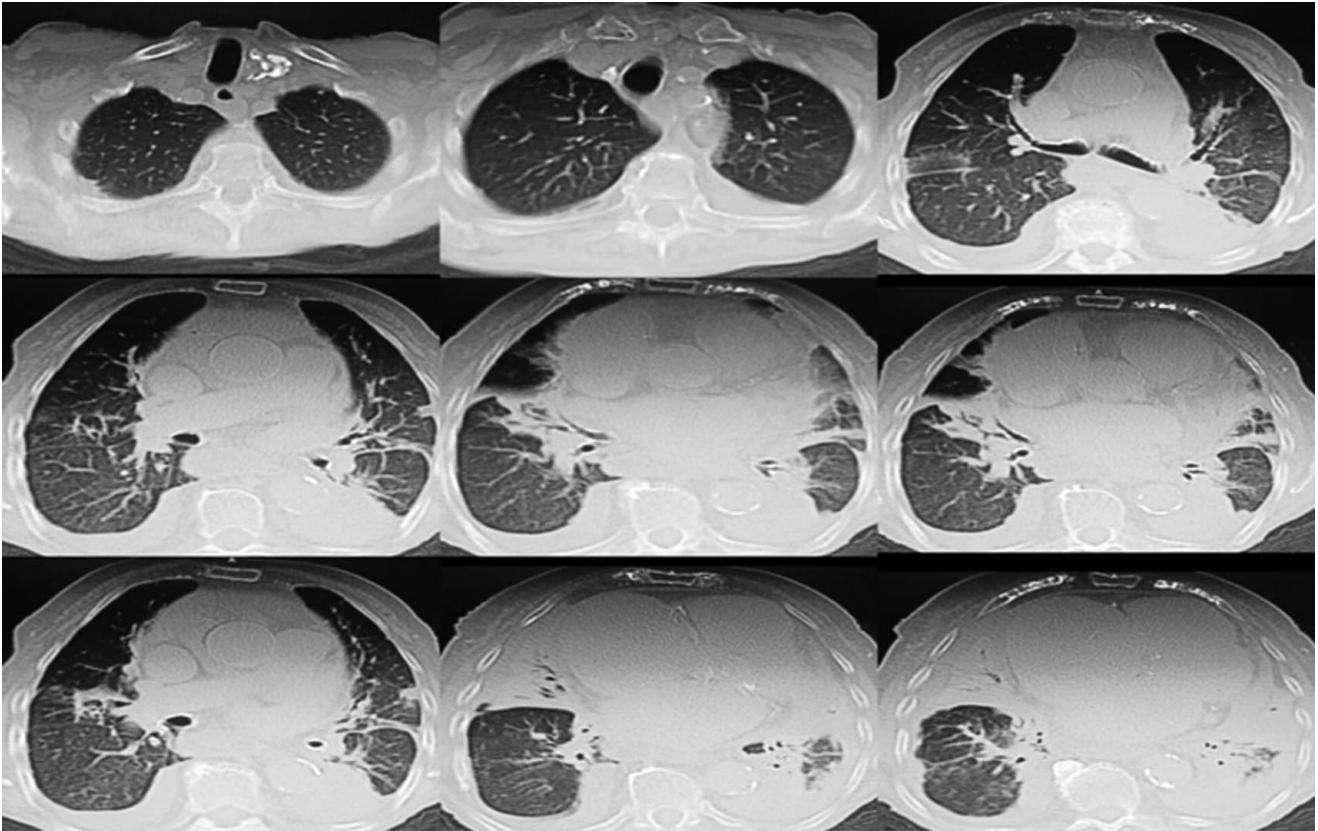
Chest computed tomography findings revealed bilateral patchy shadows.
